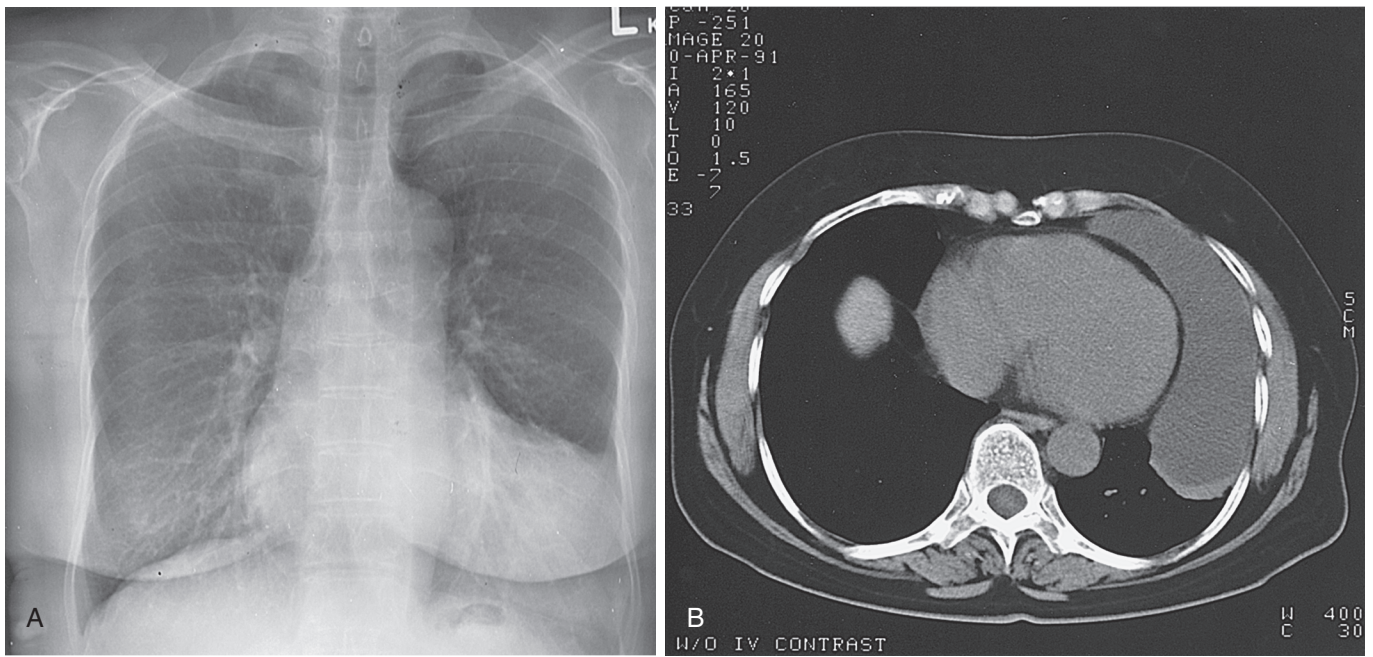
■ A, Chest radiograph of a patient with a large left-sided pericardial cyst. B, Computed tomographic scan of the same patient showing the pericardial cyst extending into the left hemithorax.
